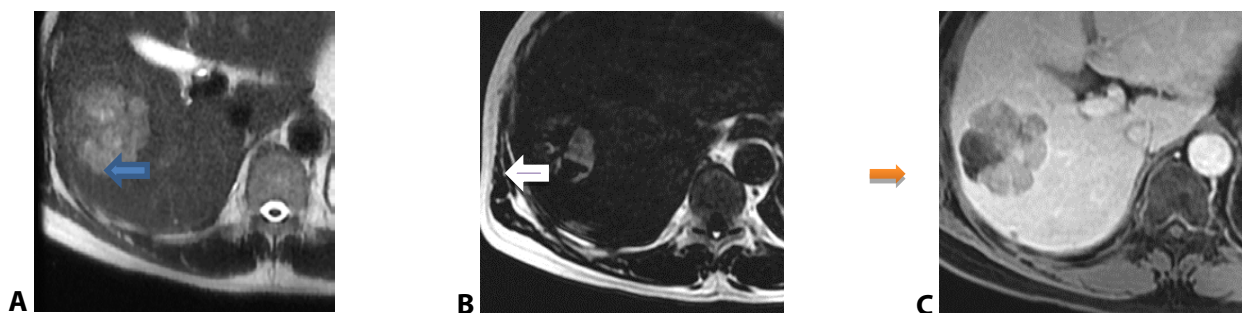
MRI scan finding of case 2. A. The tumor structure is clearly bordered and lobulated on T2W (arrow). B. Fatty components in tumor on FAT T1W 3D (arrow). C. Necrotic components do not enhance after injection magnetic resonance imaging contrast agent primovist (arrow).
